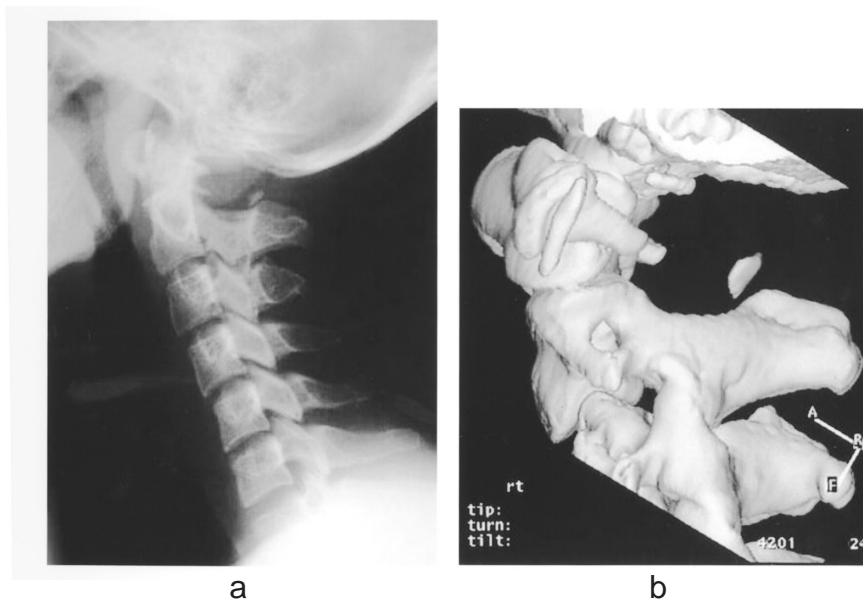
a Case 1 : A lateral radiograph of the cervical spine, showing the absence of the posterior arch of the atlas except for the posterior tubercle.
